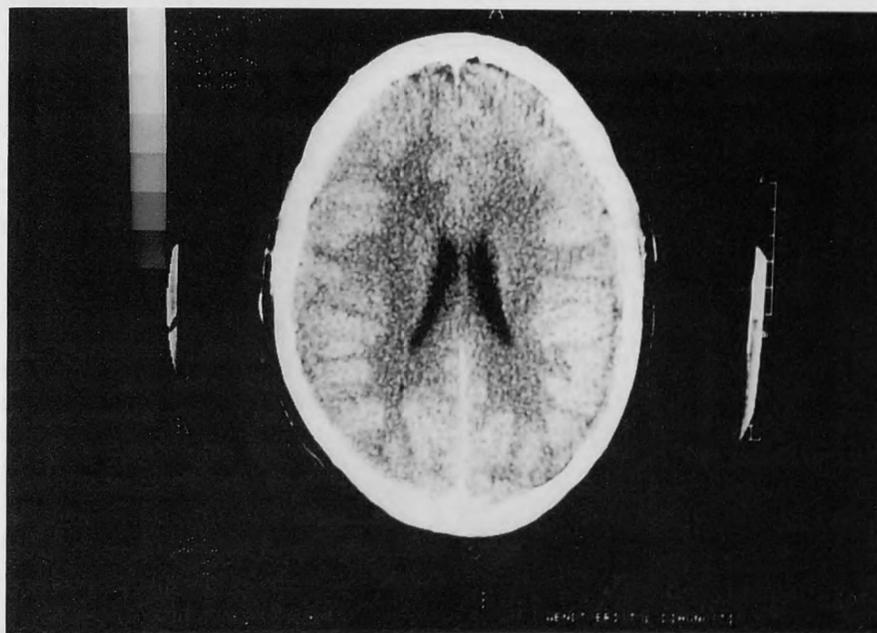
CT scan of September 20.
